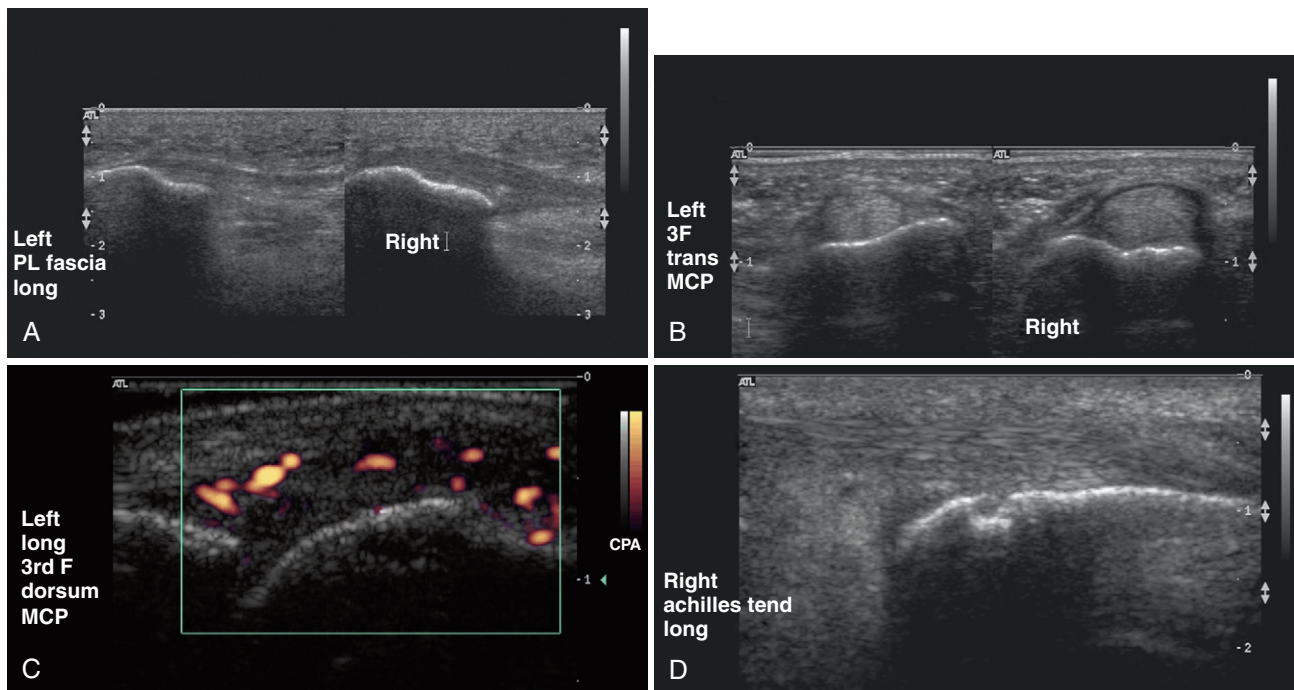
Musculoskeletal ultrasound features in psoriatic arthritis. A, Right plantar fascia thickening compared with the left. B, Transverse section through left third finger at the metacarpophalangeal joint showing right tenosynovitis. C, Power Doppler ultrasound through left third finger at the metacarpophalangeal joint confirming increased vascularity (synovitis). D, Right Achilles tendinitis with calcaneal erosion. (Courtesy Dr. Robin Gibney.)
